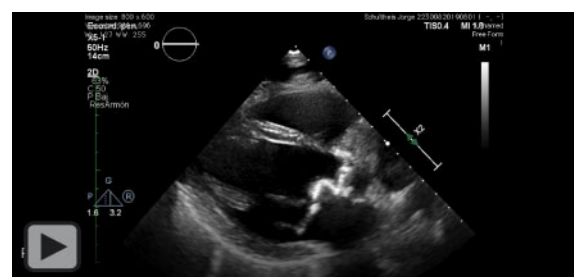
Two-dimensional transthoracic echocardiogram. (A) Long parasternal view showing the calcification of the mitro-aortic junction, involving the aortic valve and aortic root. (B) Minimal mitral regurgitation with the jet directed towards the posterior atrial wall. (C) Parasternal short-axis view exhibiting the calcification of the heart’s fibrous skeleton along the fibrous trigonous. (D) Apical four chamber off-axis view showing calcifications within the atrioventricular groove and the mitral annulus.
